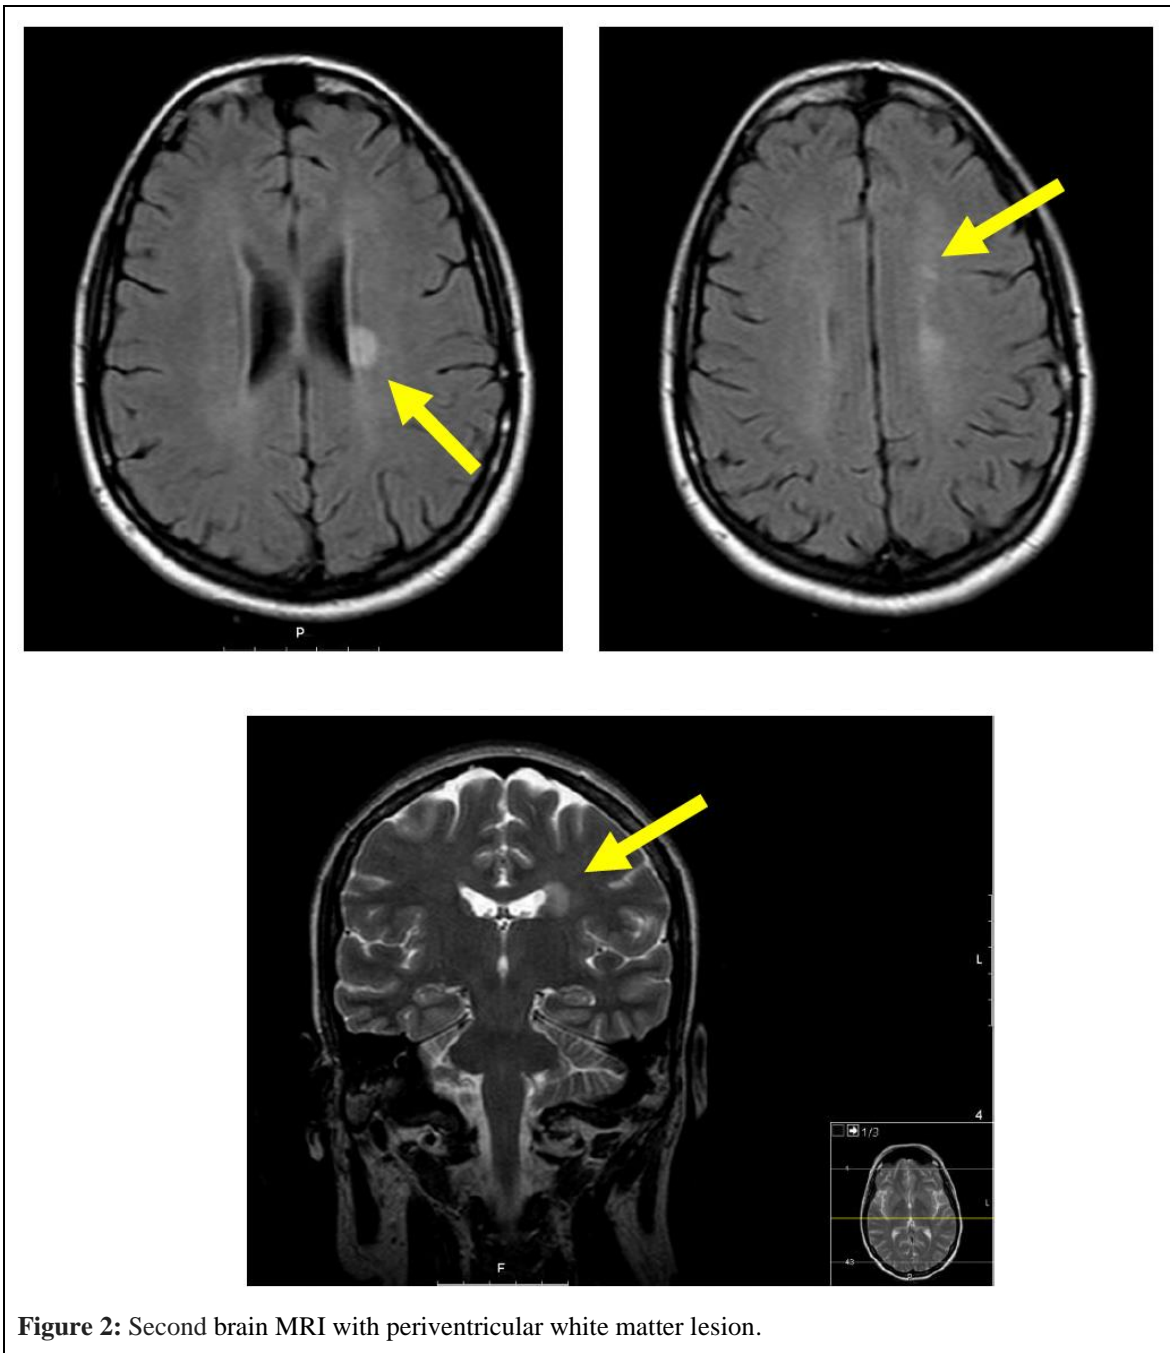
Brain MRI with periventricular white matter lesion.
